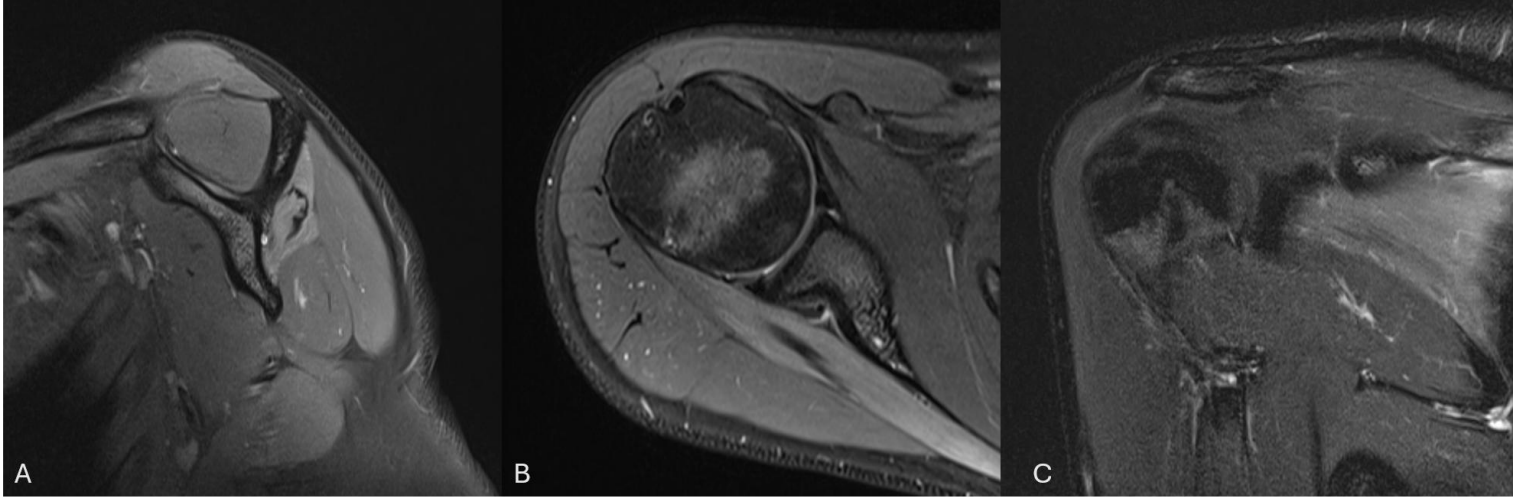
Sagittal 1B axial and 1C coronal views of T2 weighted MRI of right shoulder demonstrating neurologic edema in infraspinatus secondary to chronic compression of suprascapular nerve.
